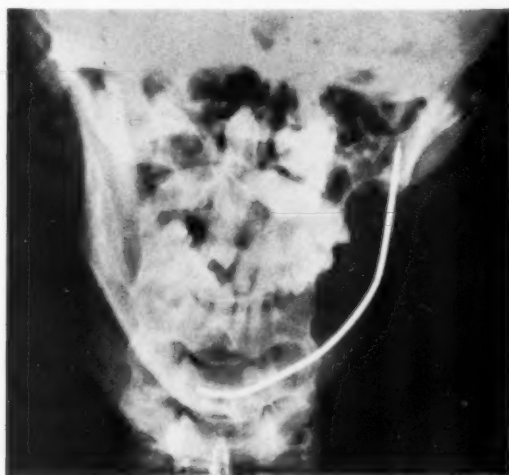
Photograph of an X-ray showing the wire used to hold apart the two cut surfaces of the mandible.
